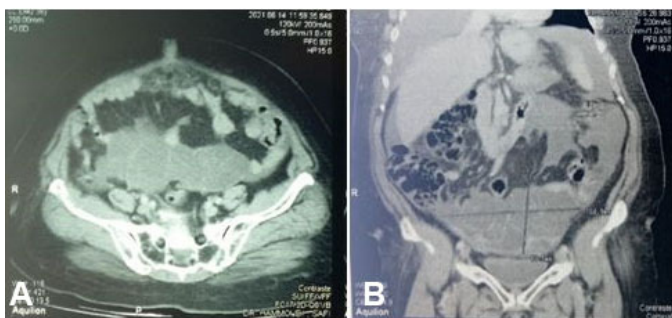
Abdominal-pelvic CT scan showing the subcutaneous nodule (A: transverse section) and the ovarian solidocystic mass (B: coronal section).
